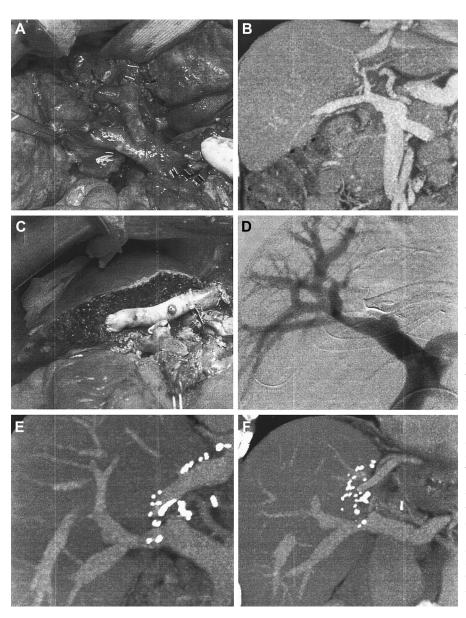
Portal vein (PV) reconstruction with the right posterior section (RPS) branch and post-transplant follow-up of PV anastomosis. Early RPS PV branching was identified during pre- and intraoperative evaluation (A and B). A right lobe graft with a graft-recipient weight ratio of 0.87 was implanted using the RPS PV branch (C). Because the recipient's RPS PV stump was rather short for direct PV anastomosis, the distal end of the RPS PV branch was used to relieve anastomotic tension. Gauze padding beneath the liver graft is visible. Graft middle hepatic vein was reconstructed with an iliac vein allograft. An intraoperative direct portography showed mild stenosis at the PV anastomosis (D). Mild PV stenosis persisted on follow-up computed tomography images taken 2 weeks (E) and 6 months (F) posttransplantation.
